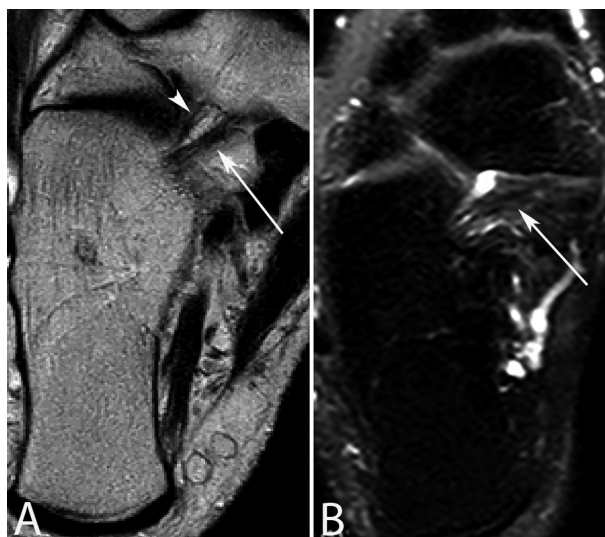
(A) TSE T1w axial MR image shows the IPL band (arrowhead) and the MPO band (arrow). (B) DP-SPAIR axial MR images are of less importance in the detection of such ligament because of the suppression of the adipose tissue, therefore the evaluation of the ligament is difficult
